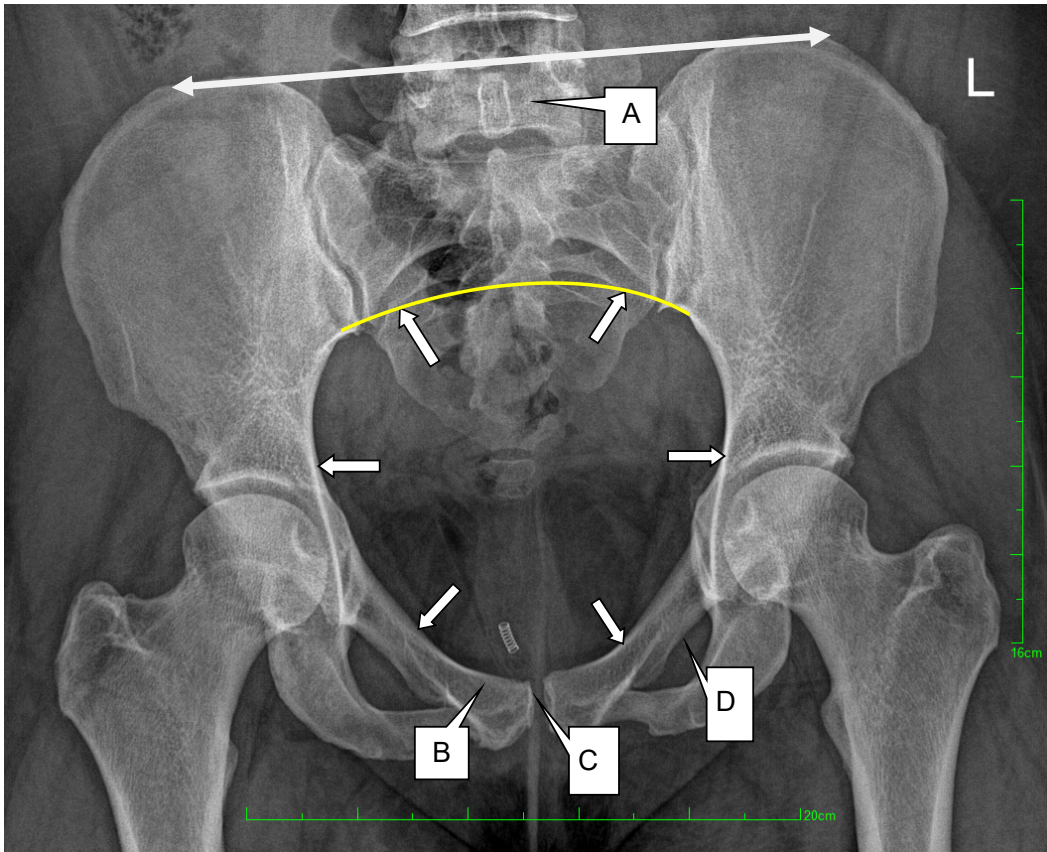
Plain radiograph of the pelvis.
